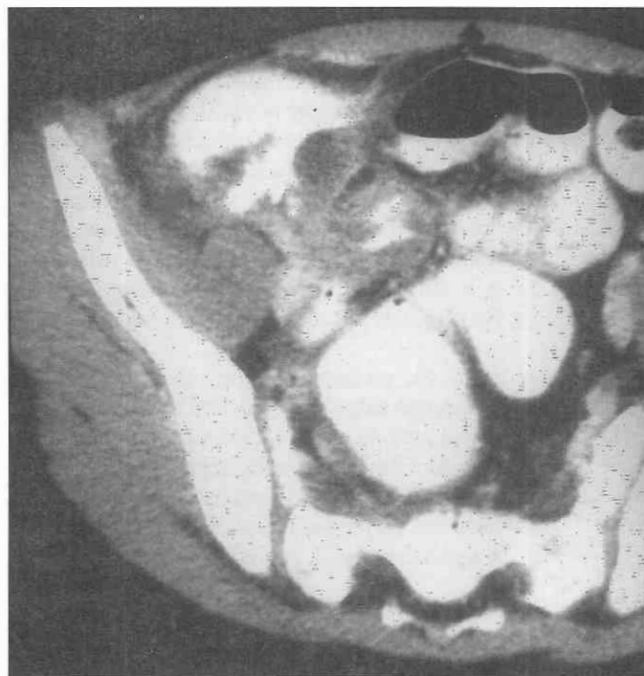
Acute appendicitis. CT scan through the lower abdomen in a child with appendicitis demonstrates the "arrow-head sign" consisting of a triangle-shaped contrast collection between the thickened cecal apical walls.
